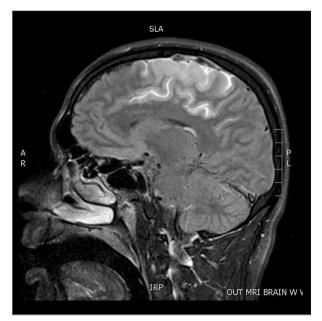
Infarction of the parafalcine frontoparietal lobe on brain magnetic resonance imaging (MRI) diffusionweighted imaging (DWI).
